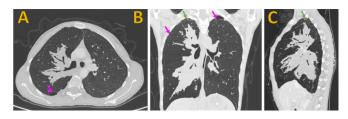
Contrast-enhanced computed tomography scan of the chest (lung window) shows hyperinflation and mild subpleural reticulation predominantly involving the apical segment of the right upper lobe (green arrows) and subpleural bullae (pink arrows).
